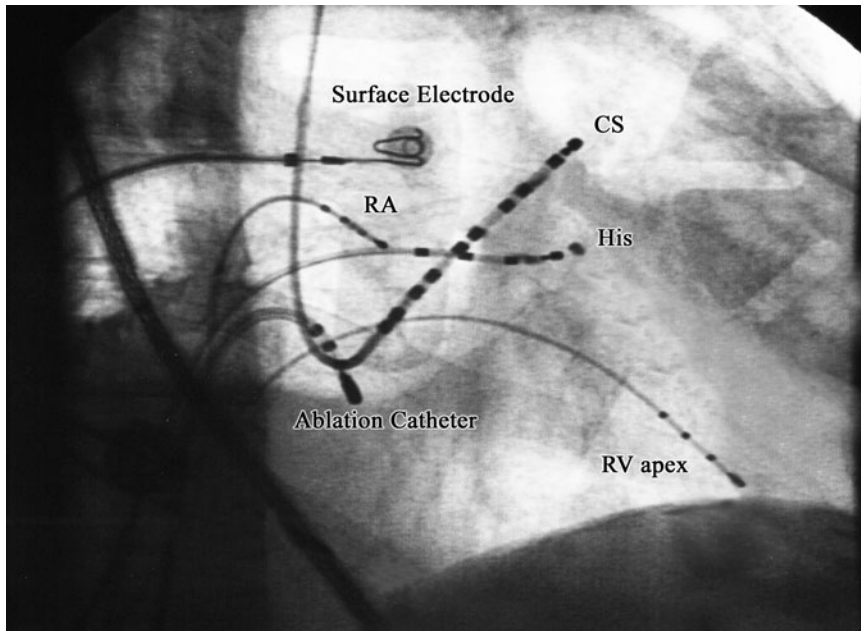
Radiograph in the right anterior oblique projection showing catheters positioned for a standard diagnostic electrophysiology procedure. Three nonsteerable diagnostic catheters are introduced from the inferior vena cava into the right heart. Two 4F catheters with four electrodes are positioned in the region of the right atrial appendage (RA) and right ventricular apex (RV apex). A 5F catheter with six electrodes is positioned across the tricuspid annulus to obtain a His bundle recording (His). A nonsteerable 6F catheter is introduced via the right internal jugular vein into the coronary sinus (CS) to obtain left atrial and ventricular recordings. Finally, a deflatable 7F ablation catheter is positioned in the region of the low right atrium.
